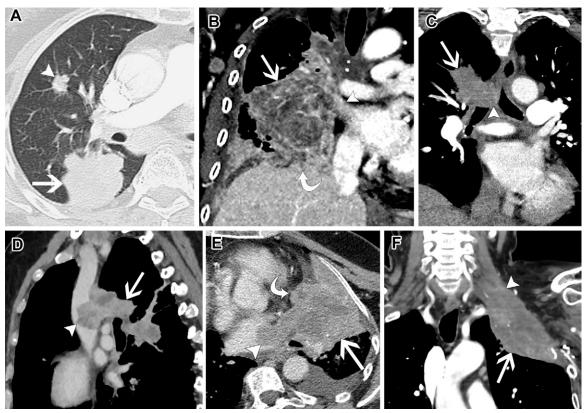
T4 lung cancer in six patients. (A) Axial unenhanced chest CT scan (lung window) in a 77-year-old woman with NSCLC shows a right-lower-lobe mass (arrow) associated with a separate tumor nodule (arrowhead) in the right middle lobe. (B) Coronal contrast-enhanced chest CT image (soft-tissue window) in a 57-year-old woman with NSCLC shows a large central mass (straight arrow) in the right lung invading the mediastinum (arrowhead) and the right hemidiaphragm (curved arrow). (C) Coronal reconstruction of a contrast-enhanced chest CT scan (soft-tissue window) in a 73-year-old woman with NSCLC shows a right-upper-lobe lung mass (arrow) invading the distal part of the trachea and the carina (arrowhead). (D) Sagittal reconstruction of a contrast-enhanced chest CT scan (soft-tissue window) in a 60-year-old woman with NSCLC shows a mass (arrow) involving both the right upper lobe and right lower lobe and protruding into the superior vena cava (arrowhead). (E) Axial contrast-enhanced chest CT image (soft-tissue window) in a 64-year-old woman with NSCLC shows left-lower-lobe lung cancer (straight arrow) invading the pericardium and the epicardial fat (curved arrow) as well as the left atrium (arrowhead). (F) Coronal reconstruction image of a contrast-enhanced chest CT scan (soft-tissue window) in a 63-year-old woman with NSCLC shows a left-upper-lobe superior sulcus tumor (arrow) invading the left brachial plexus (arrowhead) above the C8 level.
